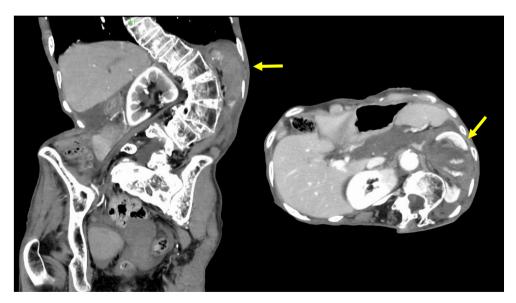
Severe left kidney laceration at the level of an acute angle in the vertebral column caused by scoliosis in an 80-year-old woman. Computed tomography scan images show that the kidney was likely crushed by the sharp lateral edges of the lumbar spine extruding into the retroperitoneal space (arrows).
